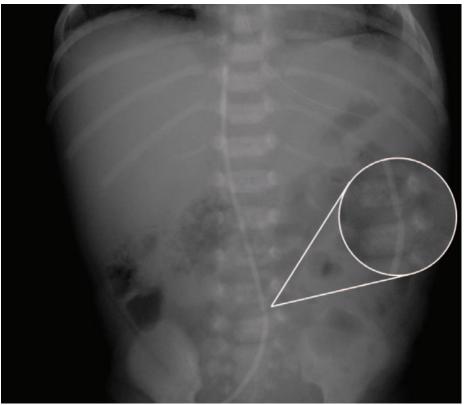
An abdominal X-ray demonstrating the UVC lying in an acceptable position but with a deformation of its radio-opaque outline at L4/5 corresponding to the point of fixation at the umbilical stump.
